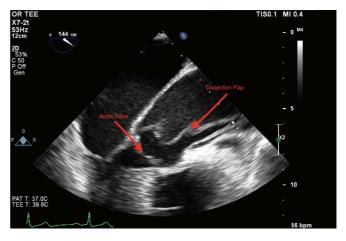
Transesophageal mid-esophageal long axis view showing aortic dissection. This transesophageal view if the aortic root clearly demonstrates a dissection flap abutting the aortic valve. Courtesy of Dr. Peter Burrage MD, Dartmouth-Hitchcock Medical Center, Lebanon, New Hampshire.
